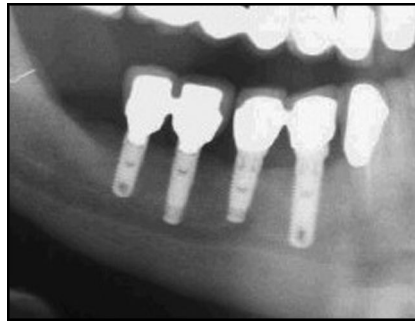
Follow-up radiograph 2 years after rehabilitation.
